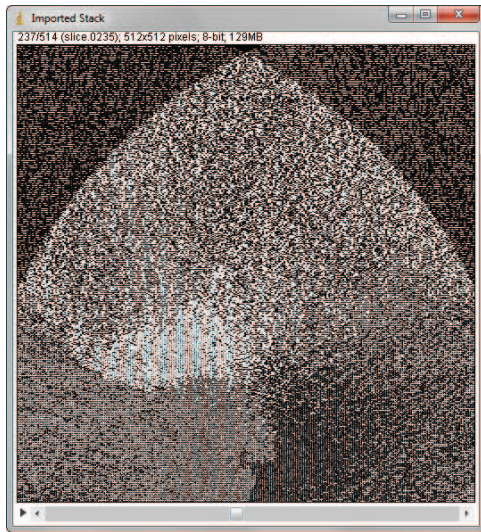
Raw, unprojected micro CT data slice of a vestibular organ in ImageJ. B conversion in DICOM file format via AMIRA.
